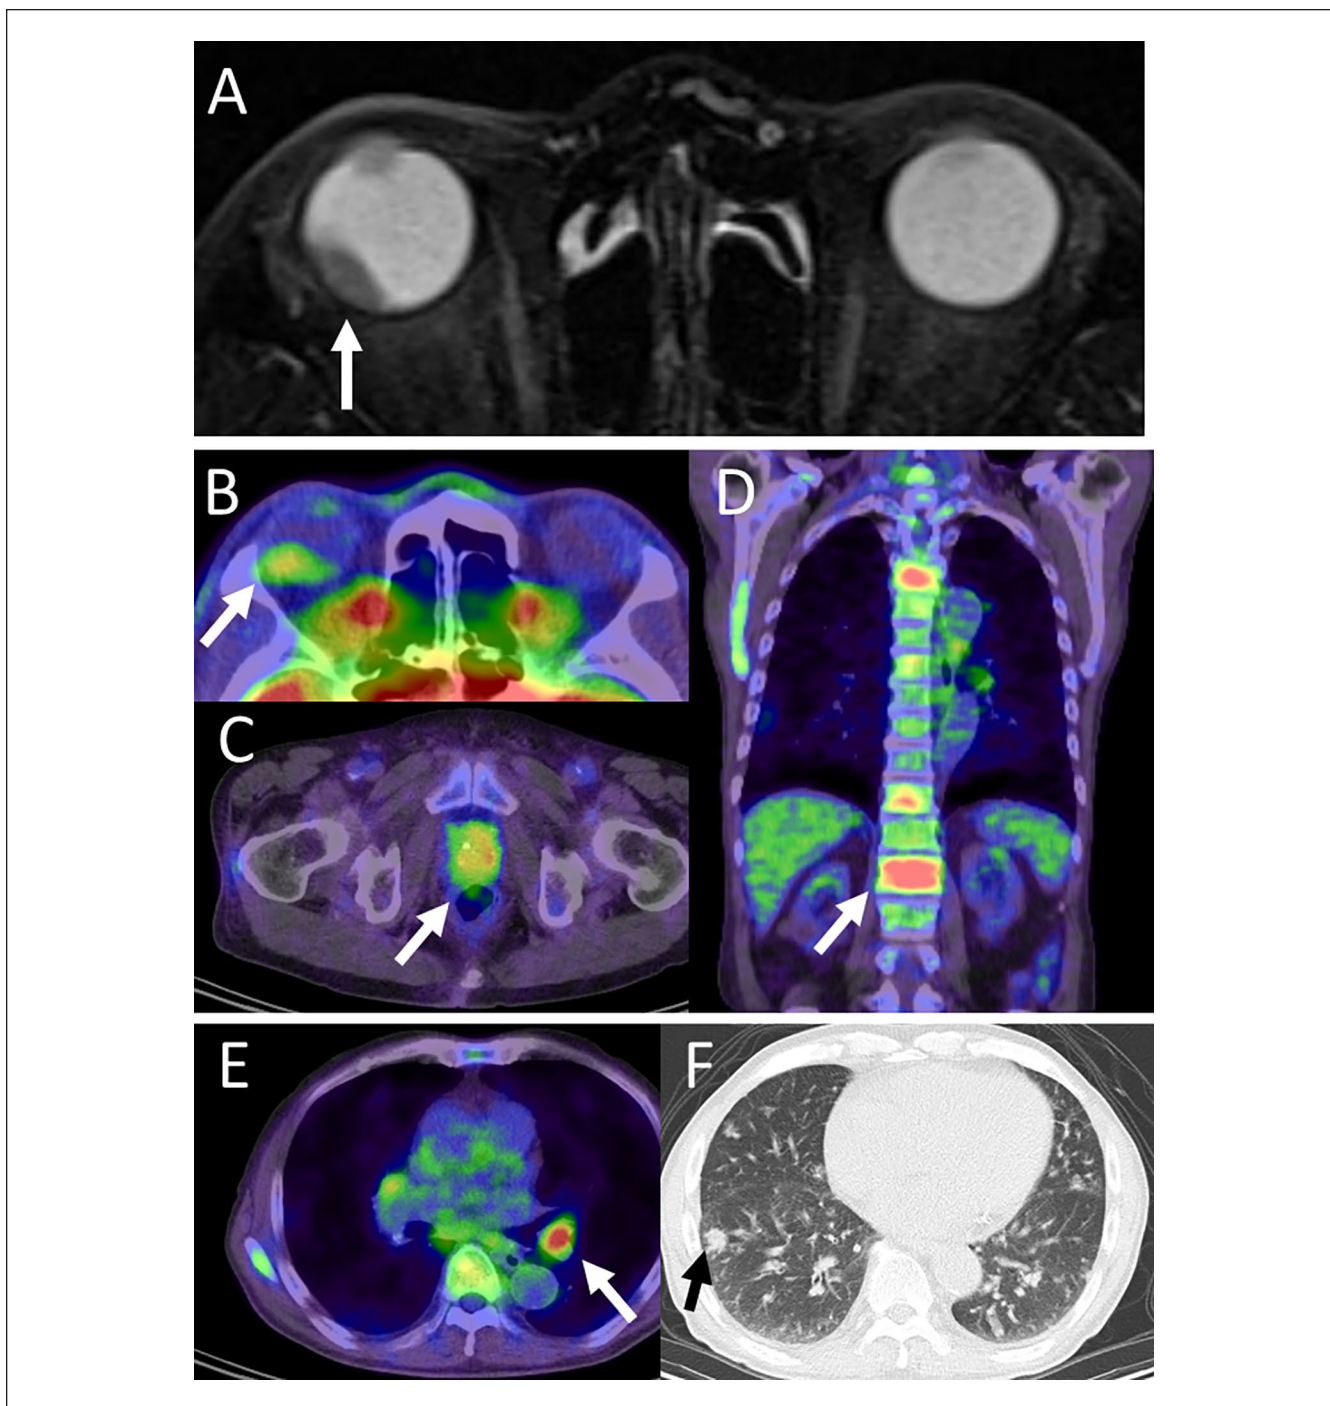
An intraocular mass (arrow in A) in the right eye with mildly low T2-weighted signal in magnetic resonance image in a 73-year-old man at the initial visit. Abnormal uptake in the right eye (arrow in B, standardized uptake value $SUV_{max} = 3.31$), prostate (arrow in C, $SUV_{max} = 4.75$), vertebral bones (arrow in D, $SUV_{max} = 8.01$), and mediastinal lymph node (arrow in E, $SUV_{max} = 5.77$) in whole-body 2- ^{18}F fluoro-2-deoxy-D-glucose positron emission tomography (FDG-PET) at the initial visit. Note multiple lung-field lesions (arrow in F) in computed tomography scan combined with PET.
